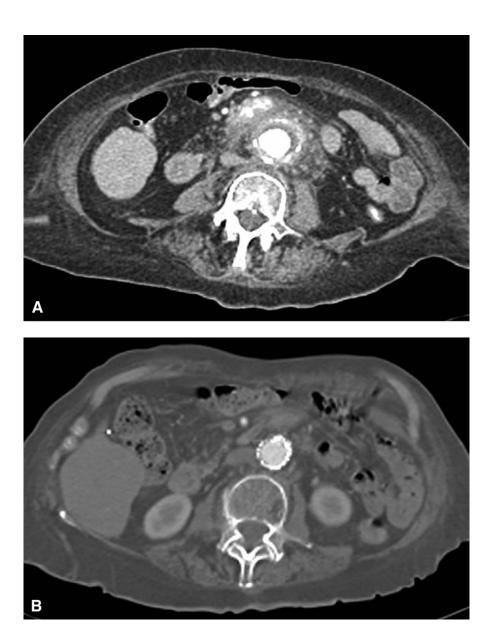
A, Computed tomographic scan performed only with intravenous contrast demonstrating inflammatory changes around the aorta and contrast within the intestinal lumen. B, Computed tomographic angiography 12 months after successful endovascular repair.
